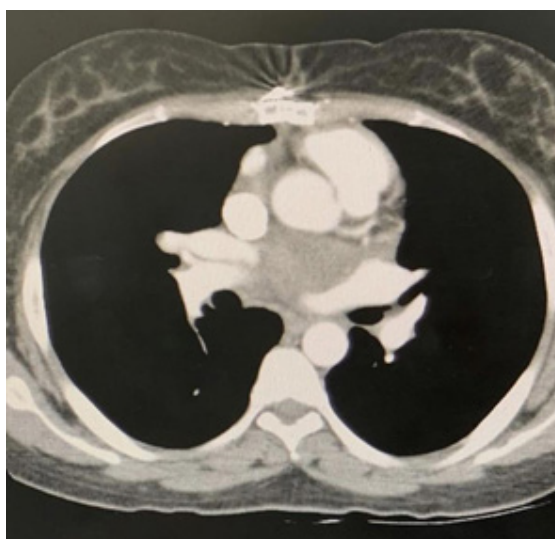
Computed Tomography Exam after third cycle of chemotherapy
